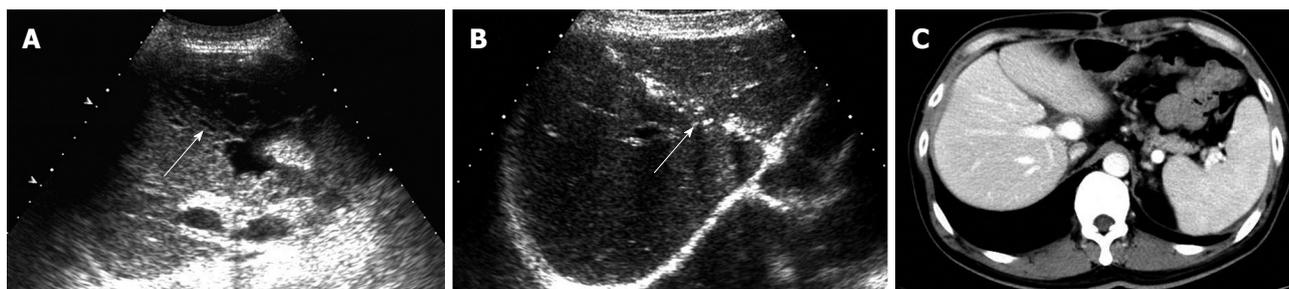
A 42-year-old man with fluid collection between the grafts after dual-graft liver transplantation. A: Gray scale sonogram shows the focal fluid collection with septa inside (arrow); B and C: The grafts joint visibly on follow-up sonogram (arrow) and computed tomography.
